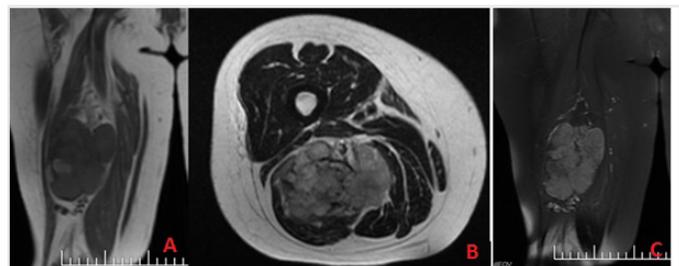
A) MRI images of posterior muscle plans of right lower thigh. The lesion seemed mildly hyperintense on T1-weighted sequences B) hypointense on t2-weighted sequences and showed C) no prominent contrast enhancement after intravenous contrast-material was injected to a lesion with lobulated contour with a size of approximately 74x39 mm
